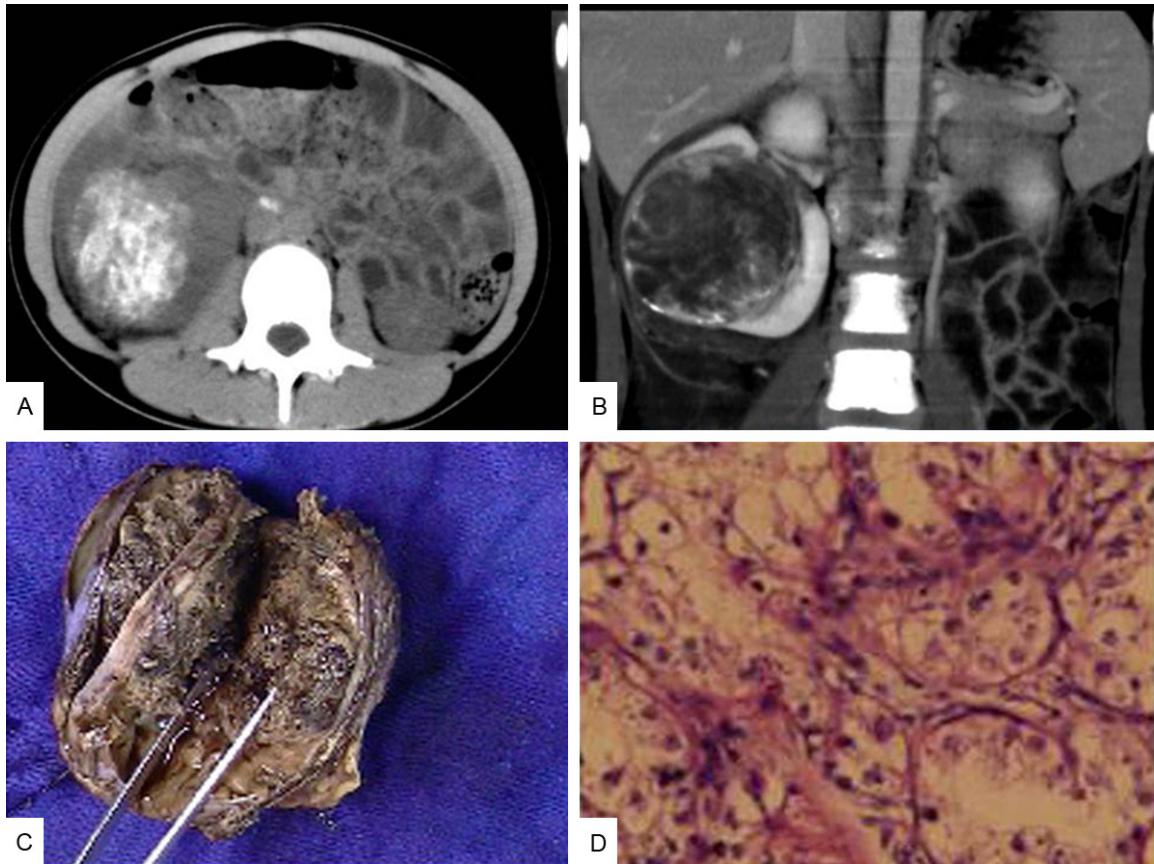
Computed tomography (CT) scans and postoperative pathological examination show that this is a case of locally progressive kidney cancer. A and B show a massive mixed-density lesion measuring $60 \times 70 \times 70 \text{ mm}^3$ in the middle and lower parts of the right kidney and a round mixed-density nodule measuring $10 \times 16 \text{ mm}^3$ in the retroperitoneal area, indicating metastasis of right renal cancer to the retroperitoneal lymph nodes. C shows a mass of $60 \times 60 \text{ mm}$ that has broken through the renal capsule. D shows clear cell carcinoma classified as nuclear grade II.
